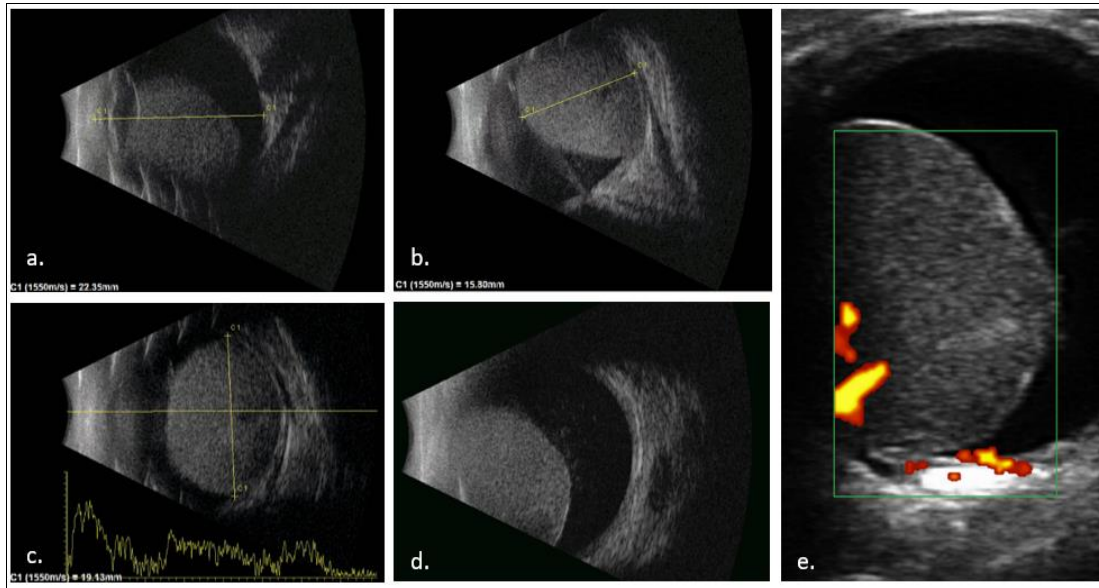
US. Left eyeball ultrasound. a., b., and c. Phakic eyeball with a coroidal lesion in the temporal inferior border that extends from M3 to M6, elevated, domed, homogeneous ecogenicity with coroidal excavation. d. Vitreous humor with some puntiform echoes suggestive of haematic content. e. Power Doppler ultrasound with evidence of intralesional vessel
